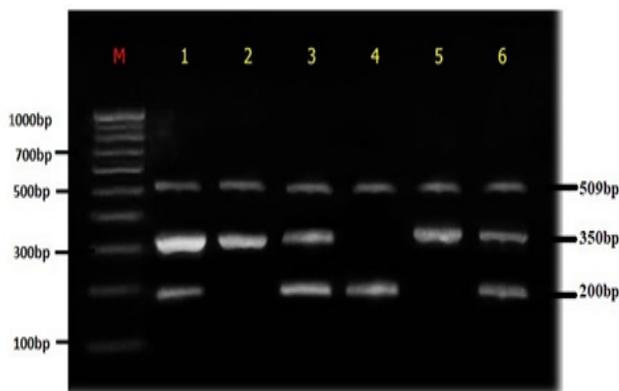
T-ARMS PCR Analysis of PPAR γ gene. (M)-100 bp Molecular marker; Lane1, 3, 6 (CT-509bp, 201 bp, 350bp); Lane 2, 5(CC-509bp, 200bp); Lane 4 (TT-509 bp, 350bp).
